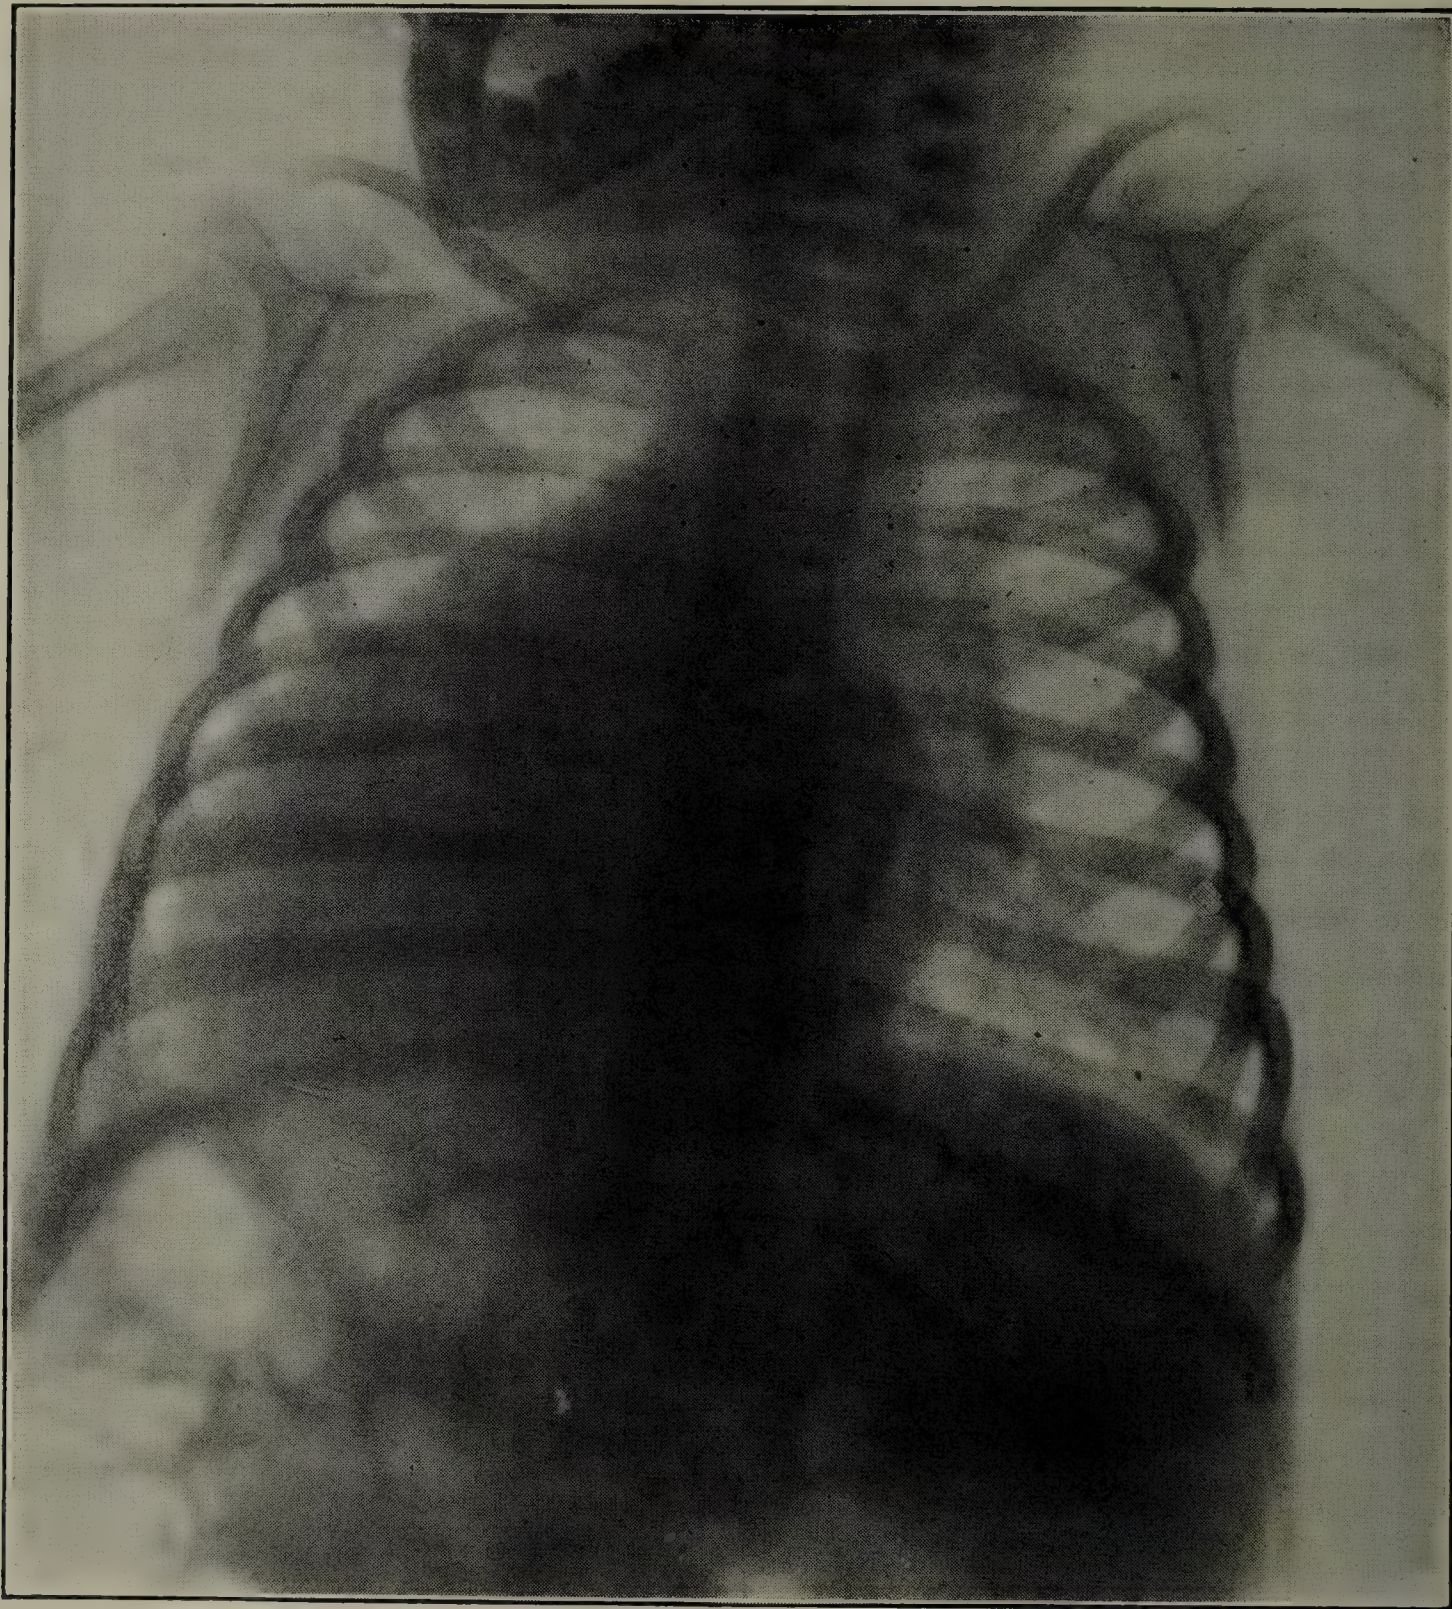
ROENTGENOGRAM OF IDIOPATHIC CARDIAC HYPERTROPHY IN INFANT TWO MONTHS OLD.
